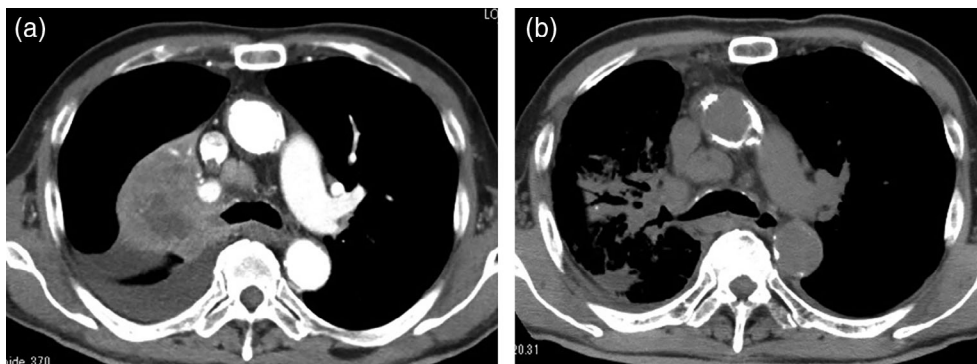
Computed tomography (CT) image of the chest. Chest CT image of a 68-year-old man with a high incidence of tumor proportion score (TPS) (95%) with lung adenocarcinoma complicated by carcinomatous pleurisy. Pembrolizumab therapy was administered as initial therapy, but was discontinued after two cycles due to progressive disease (PD). Atezolizumab therapy was started as fourth-line therapy, and the airway obstruction was resolved by tumor shrinkage. The patient's respiratory status improved, and he no longer required home oxygen. Atezolizumab therapy was continued for 19 cycles. (a) Pretreatment contrast chest CT showed a right hilar mass protruding into the airway. (b) Plain chest CT after rechallenge with ICIs showed a reduction in the size of the right hilar mass
